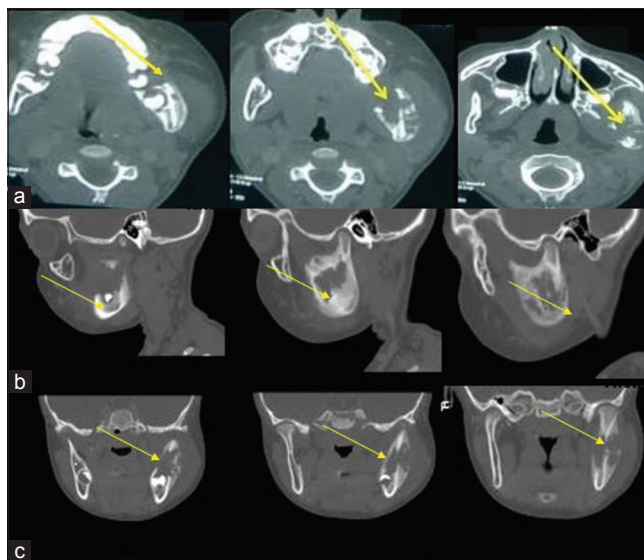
(a) Axial, (b) Sagittal and (c) Coronal sections of computed tomography scan showing areas of ill-defined destruction and pathologic fracture of the ramus of the mandible. Also aggressive periosteal reaction can be noted giving a sun ray-like appearance
